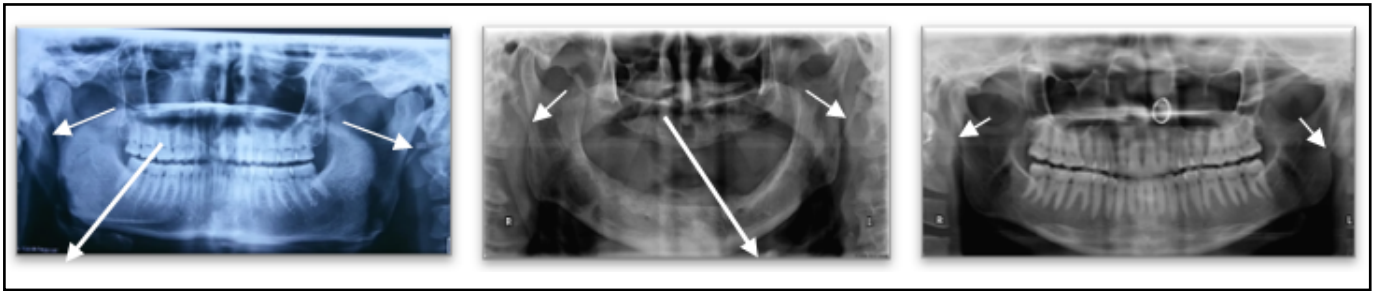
Orthopantomogram showing elongated styloid process of our patients
